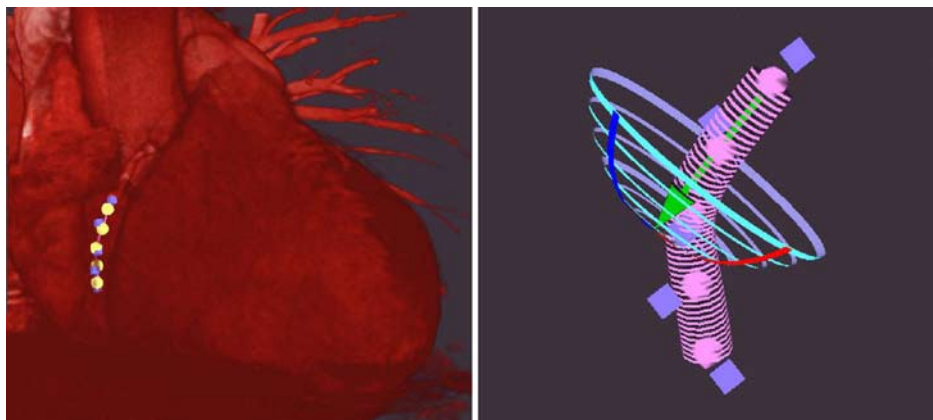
The panel on the left shows the co-registered points applied to the MSCT image that was imported into Navigant and the panel on the right shows the computer reconstructed pathway that is derived from CT and projected onto the reconstruction in Navigant.
